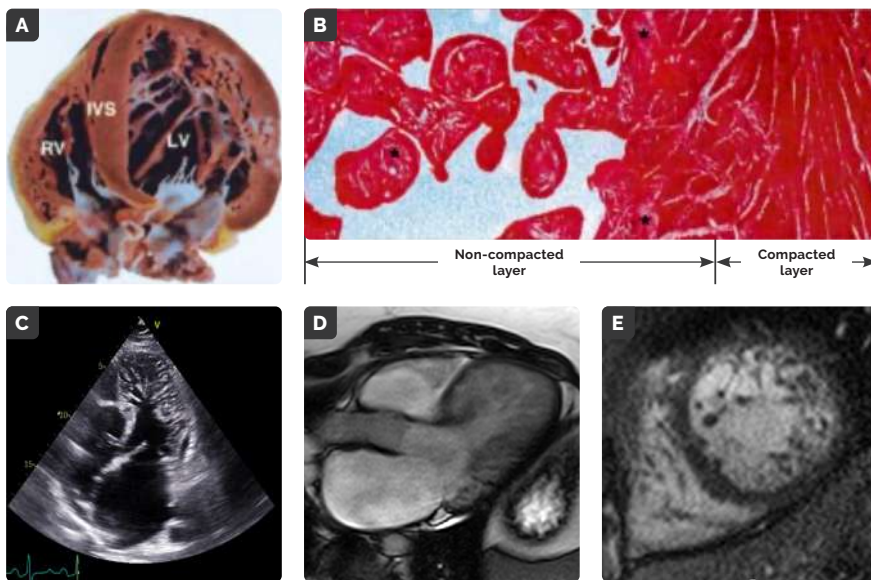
A - B:* Adaptado de Jenni *et al*⁷. Hallazgos. *A)* anatómicos e *B)* histológicos de un paciente con no compactación del ventrículo izquierdo. *C - E:* Adaptado de Casas *et al*⁸. Hallazgos por *C)* ecocardiografía transtorácica (eje apical 4 cámaras) y por resonancia magnética cardiovascular *D)* eje apical 3 cámaras y *E)* eje corto basal, de pacientes con no compactación del ventrículo izquierdo.
